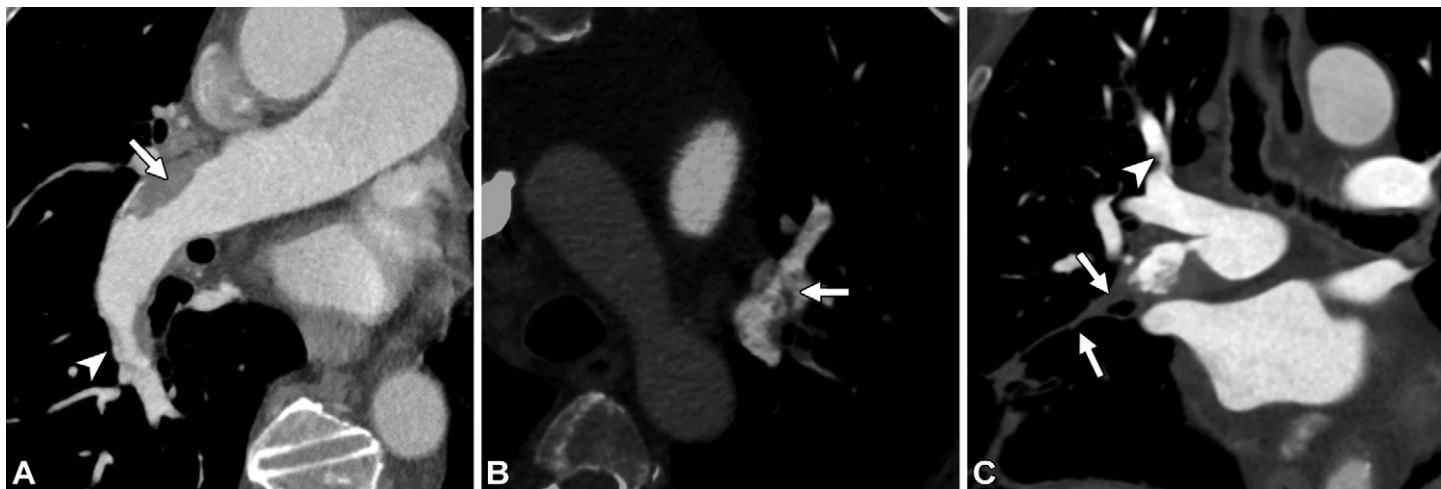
Common findings in CTEPD. (A) Axial oblique CT image shows a nonocclusive linear band (arrowhead) in the right lower lobe superior segment pulmonary artery branch. In addition, there is a larger focus of adherent thrombus (arrow) in the interlobar pulmonary artery. Even though these lesions are nonocclusive, they still cause impairment of blood flow, which can lead to increased pulmonary pressures. (B) Axial CT image through the left upper lobe anterior segment shows numerous interweaving bands of chronic clot (arrow), creating a web. (C) Coronal oblique CT image shows a chronic occlusive thrombus (arrows), which leads to vascular contraction and obliteration. Compared with acute pulmonary embolism, where thrombus leads to vascular dilatation, in chronic disease vessels rapidly taper and may seem to disappear. Also note the waistlike narrowing (arrowhead) in the apical segmental artery of the right upper lobe.
